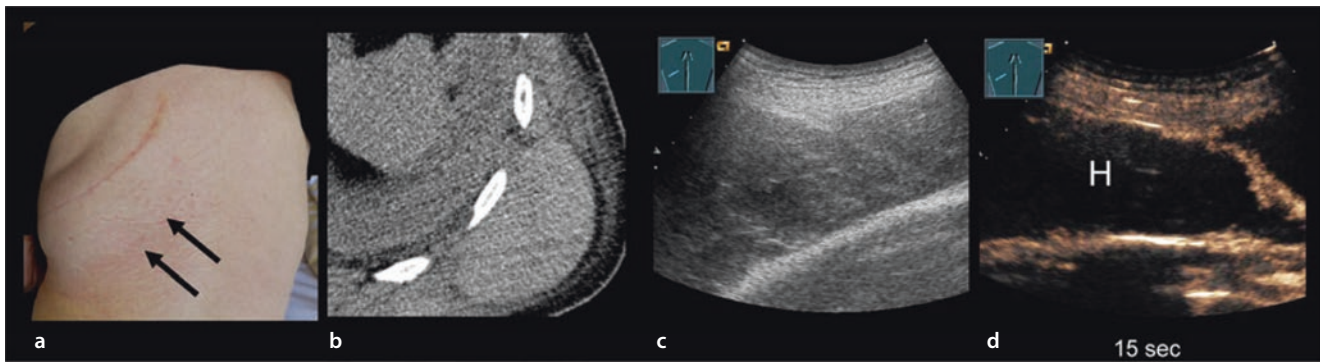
a Patient with a primarily operated bronchial carcinoma and now a space-occupying lesion in the region of the scar (*arrow*). b CT reveals the space-occupying lesion in the chest wall. c The
